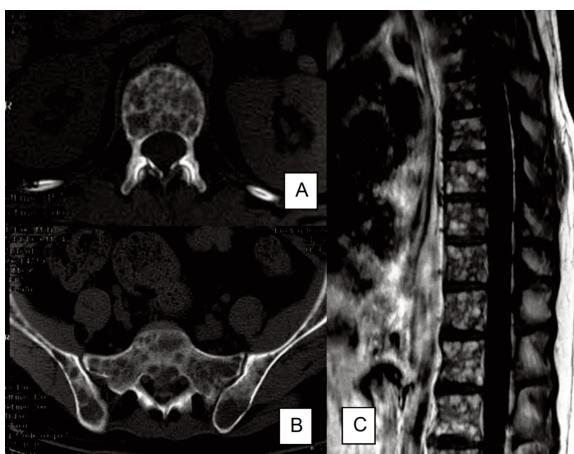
Multiple diffused well-defined osteolytic lesions in all lumbar vertebrae, sacrum and ilium on computed tomography (A,B) and magnetic resonance imaging (C).
